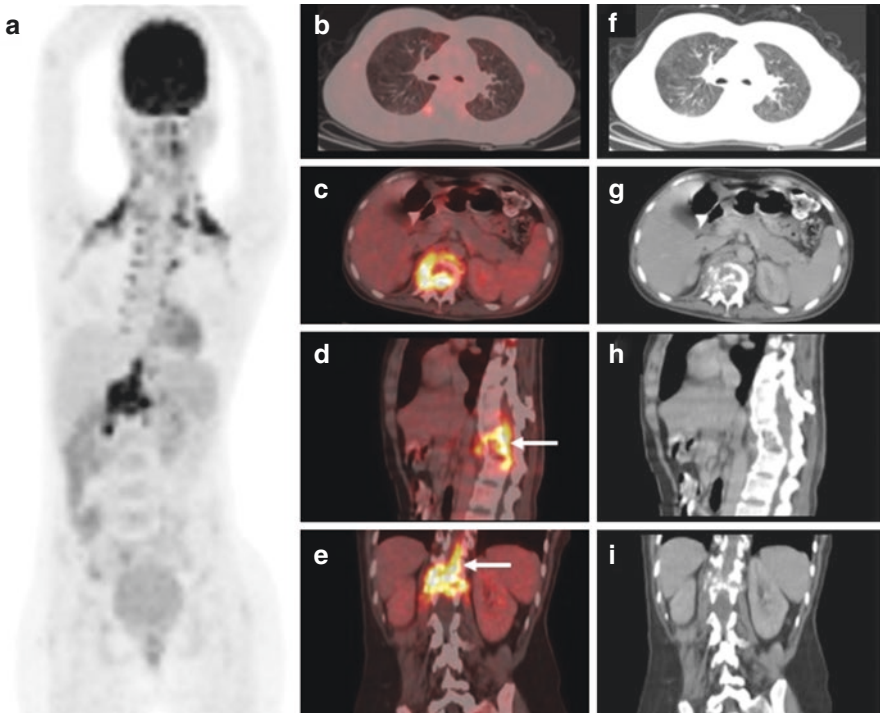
The patient underwent 18F-FDG PET/CT 4 months after initiation of ATT. Maximum Projection Image (MIP) (a), PET/CT fused (b, c, d, e), and CT only (f, g, h, i) images show resolution of lung lesions. D11-L1 vertebral lesion shows the persistence of tracer activity with an increase in the extent of the associated soft tissue component (d, e, white-arrows), suggestive of disease progression. A repeat biopsy from the skeletal lesion revealed drug resistance to rifampicin and isoniazid (MDR-TB)
